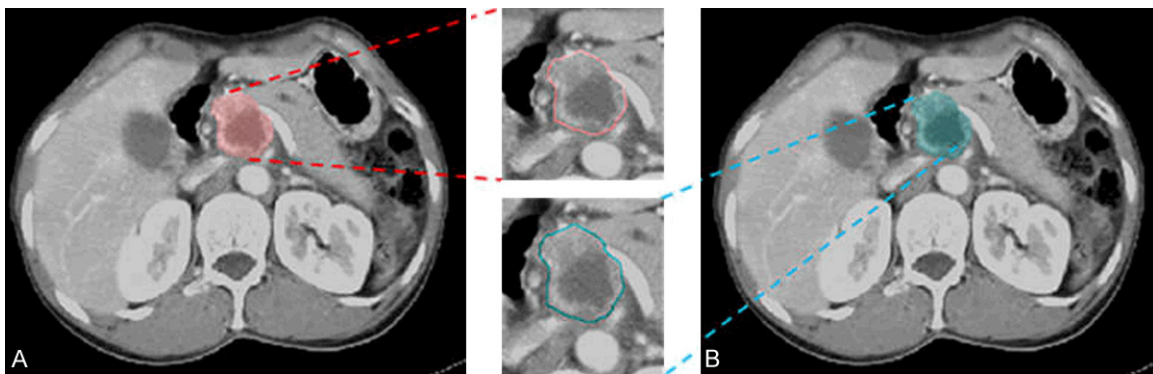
Segmented tumor images from the same patient's CT data. Different colors indicate the segmentation from the different radiologists. (A) The ROI segmented by Dr. A; (B) The ROI segmented by Dr. B.
